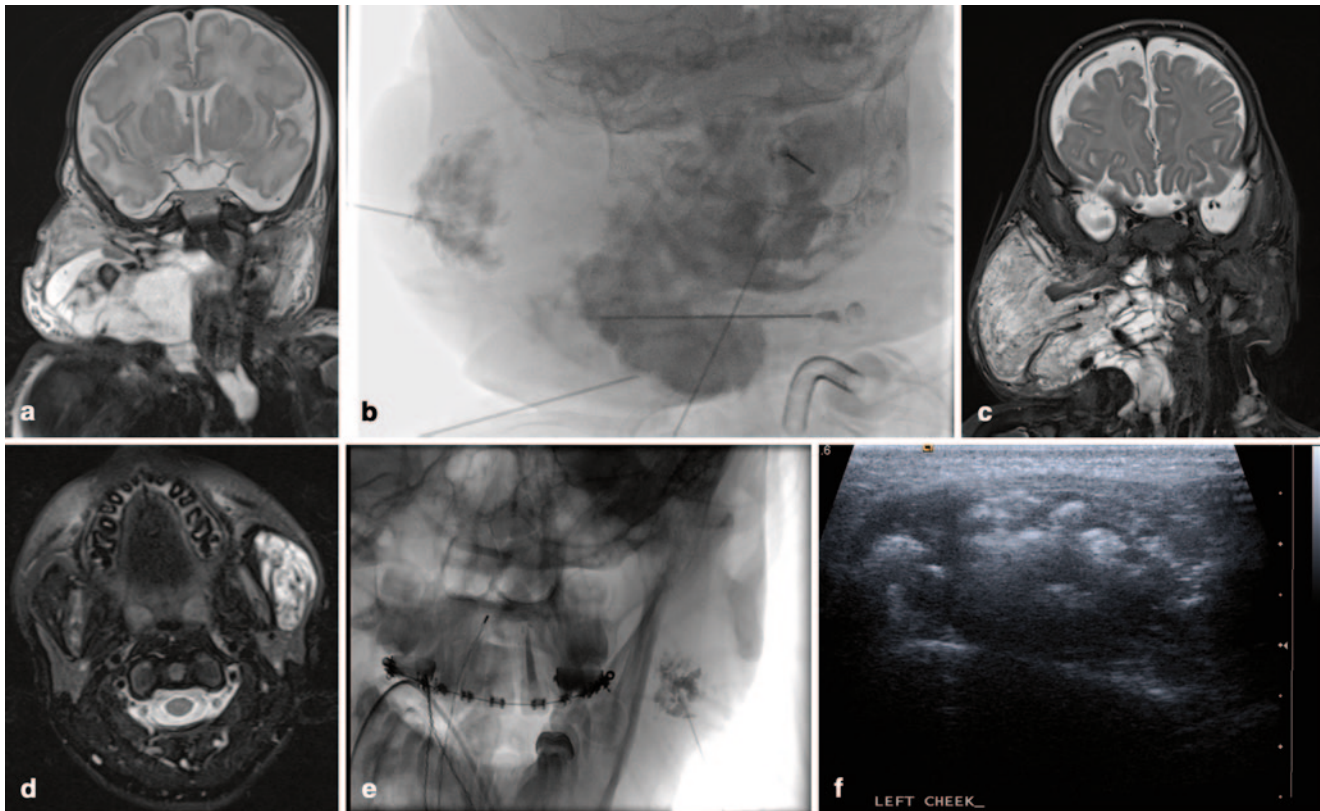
Low-flow lesions: a Coronal T2-weighted MRI of newborn with large multicystic cervicofacial mass, consistent with macrocystic lymphatic malformation. b Anteroposterior (AP) fluoroscopic image of the neck during percutaneous sclerotherapy of multiple macrocysts. c Postsclerotherapy MRI demonstrating reduction of the macrocystic
